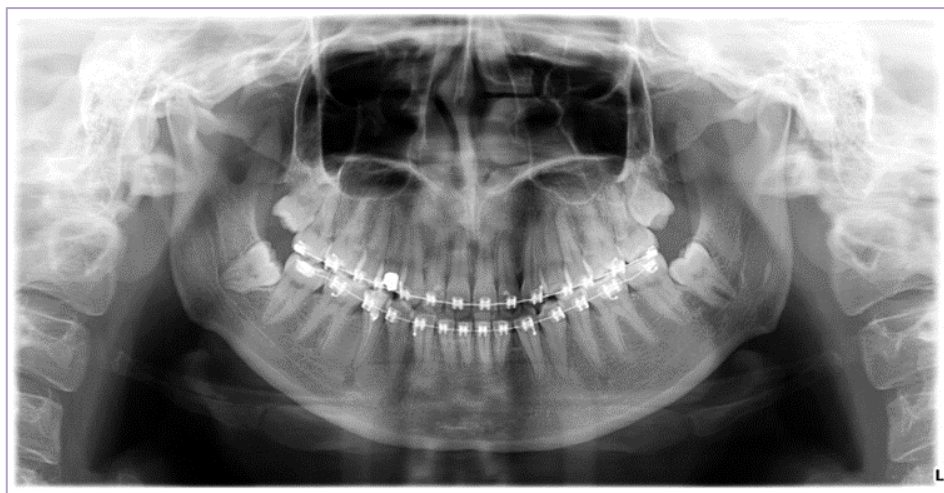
Panoramic radiograph at the end of orthodontic treatment
